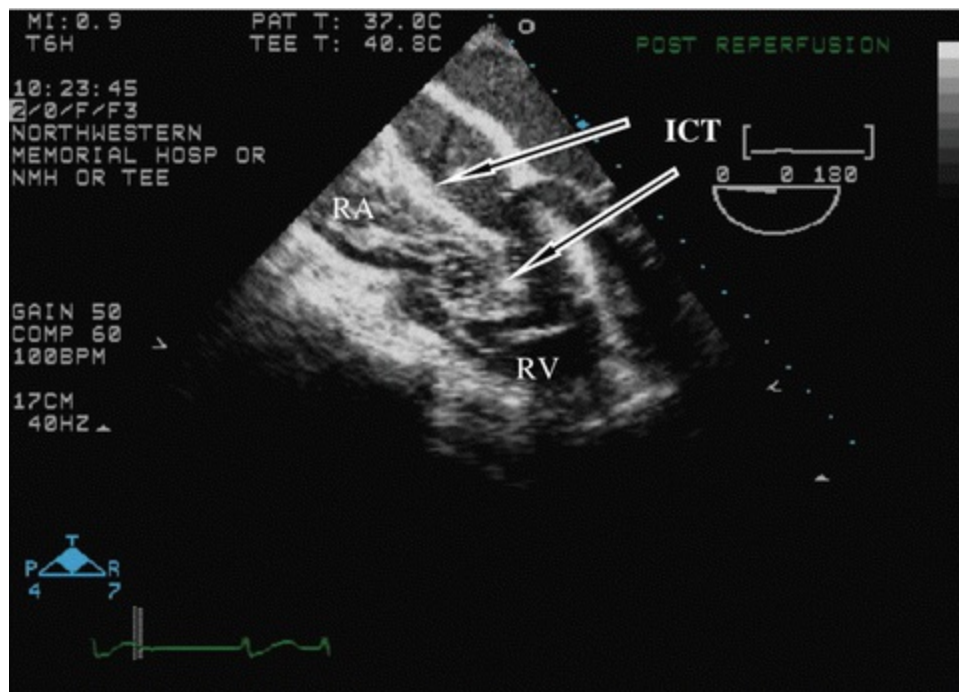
TEE of intracardiac thrombosis (ICT) . Transesophageal echocardiography (four-chamber view) in a patient with ICT. Clots can be observed in the right atrium (RA) and right ventricle (RV). Note the leftward shift of the interatrial and interventricular septa (from Boone et al. [92], with permission)
